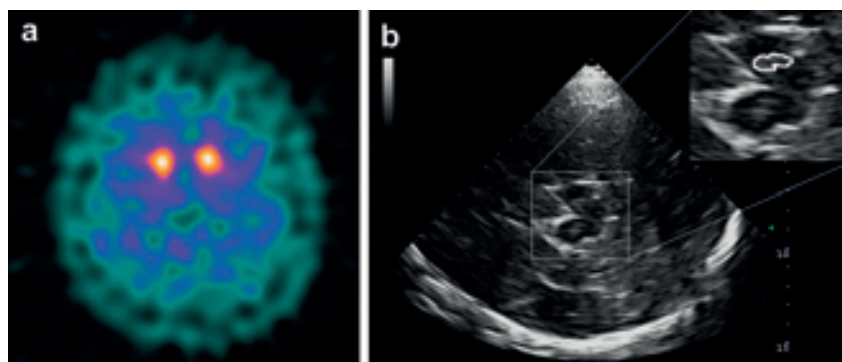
Patient with Parkinson's disease. (a) Detection of pathologic visual grade 2 with striatal binding ratio 1.76 by [¹²³I]ioflupane single photon emission computed tomography. (b) Detection of pathologic finding of substantia nigra with 0.34-cm² echogenic area by transcranial sonography.
